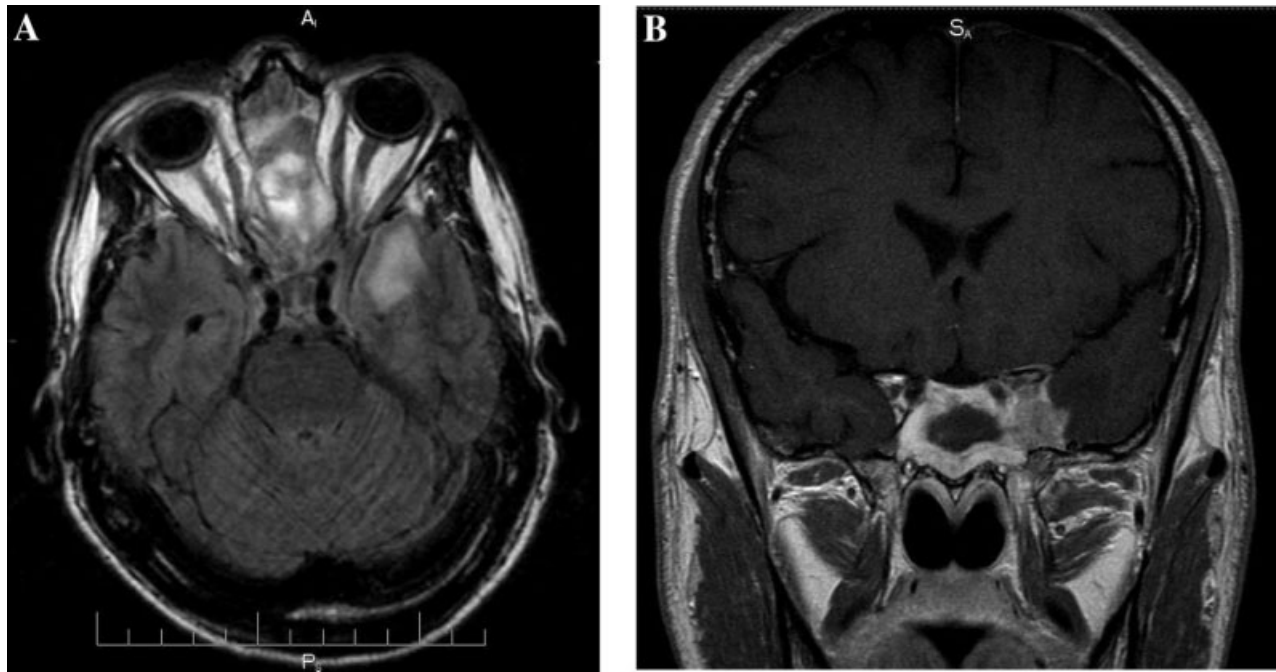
Axial (FLAIR) (A) and coronal T1-weighted (B) MR image of patient with sphenoid sinus squamous cell carcinoma with radiographic evidence of invasion of the brain parenchyma.
